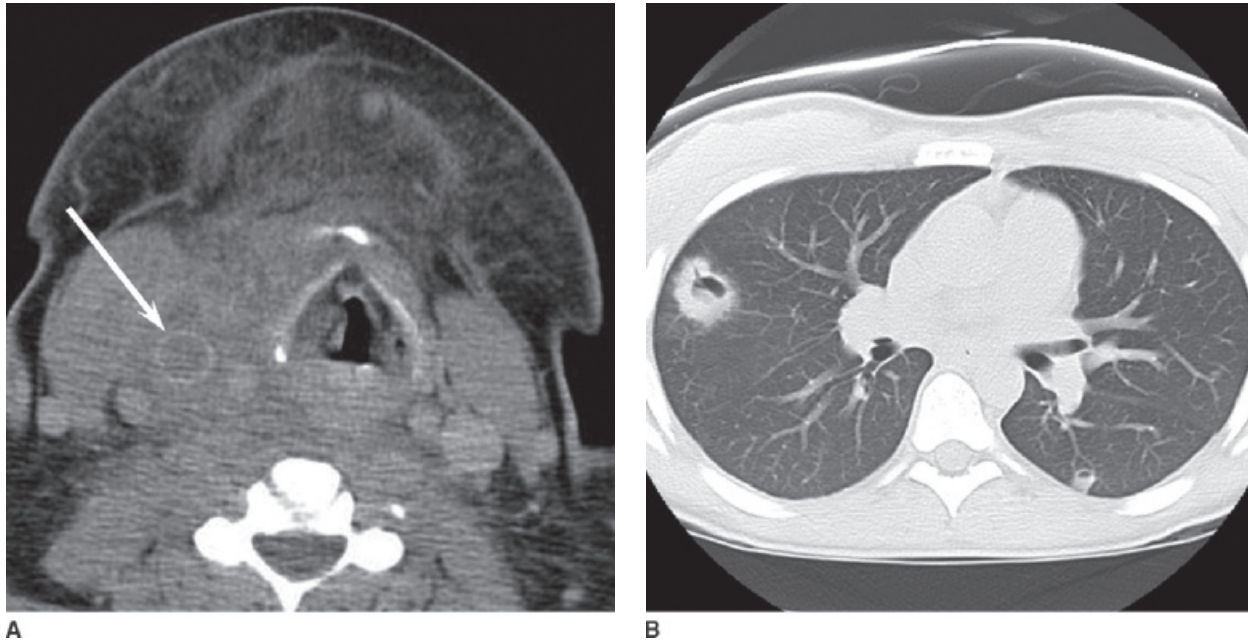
Internal jugular thrombophlebitis with Lemierre syndrome. A: Axial unenhanced CT shows hypodensity of the right IJV (arrow) with extensive surrounding fat infiltration. On contrast-enhanced CT, the vein would fail to enhance like the other vessels. Ultrasound may also be used to document disruption of venous flow. B: Axial CT on lung windows shows multiple cavitary lung masses with ill-defined borders, representing lung abscesses from infected emboli (Lemierre syndrome).
